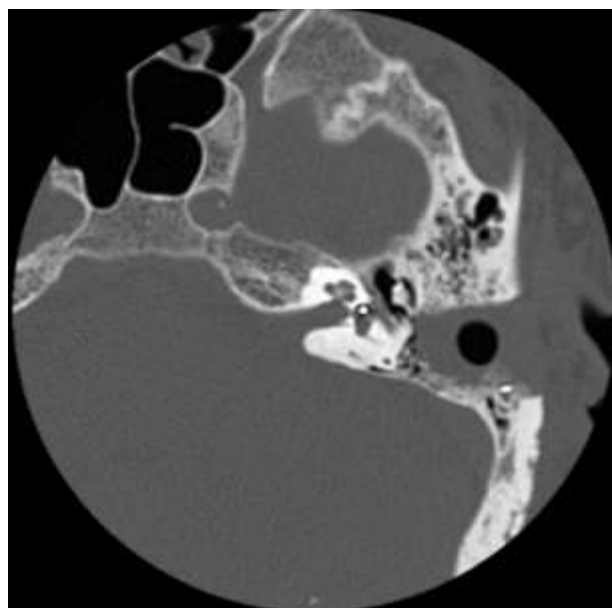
Axial CT-scan showing placement of electrodes on anterior aspect of the vestibule.
